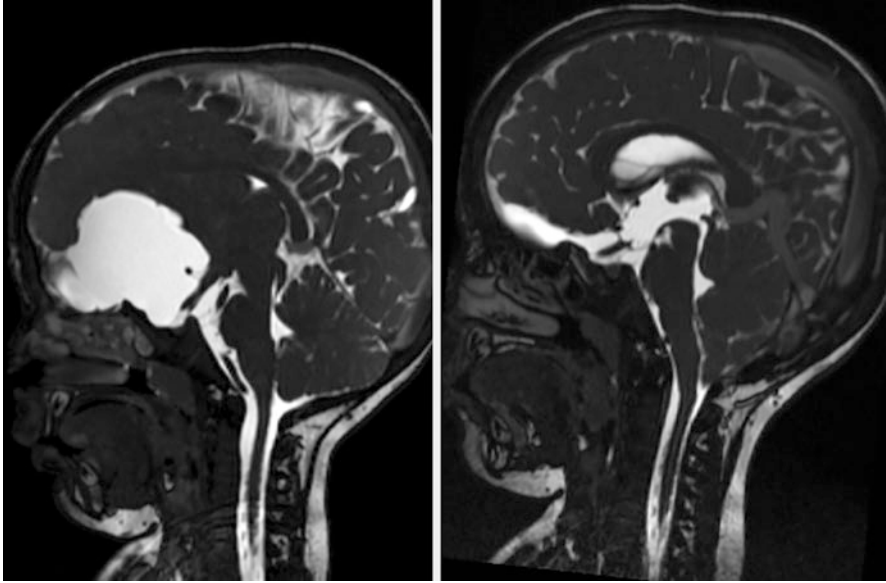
Left: Midsagittal CISS MR image of a one-year-old child with huge perisylvian arachnoid cyst. Right: Midsagittal CISS MR image one year after insertion of a cystoperitoneal shunt showing the tonsillar herniation and the engorged venous sinuses
